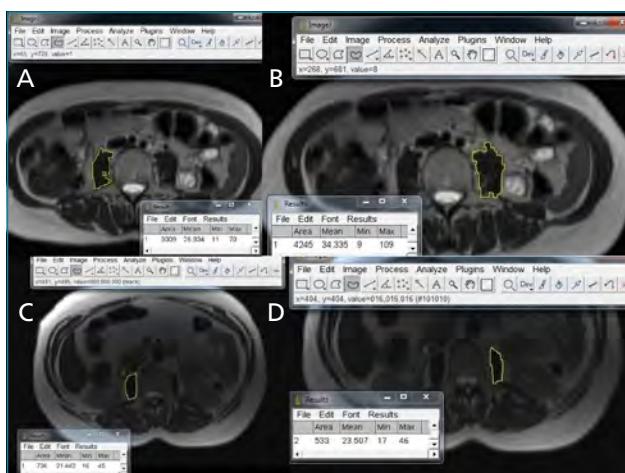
Manual psoas muscle area measurement is seen using preoperative magnetic resonance imaging scans. Measurement of right and left psoas muscle area are seen (A, B) in a 43-year-old female patient's axial T2 magnetic resonance imaging scan. Her total psoas muscle area is within normal limits. (C, D) Sarcopenia is detected in a 58-year-old female patient's axial T2 magnetic resonance imaging scan. Her psoas muscle area is 1269 mm² (less than 1464 mm²).
